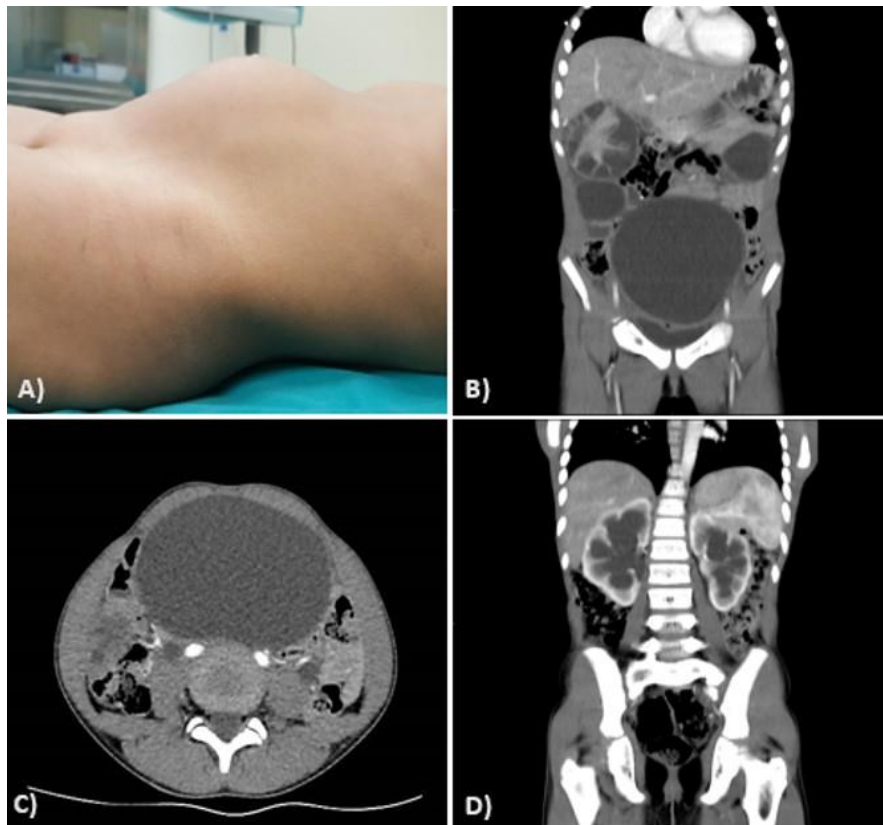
Images of abdominal swelling and Computed Tomography (CT). A) The appearance of abdominal swelling, B) Image of all cysts in coronal section of CT, C) Pelvic cyst in transverse section of CT, D) Bilateral hydronephrosis in coronal section of CT
